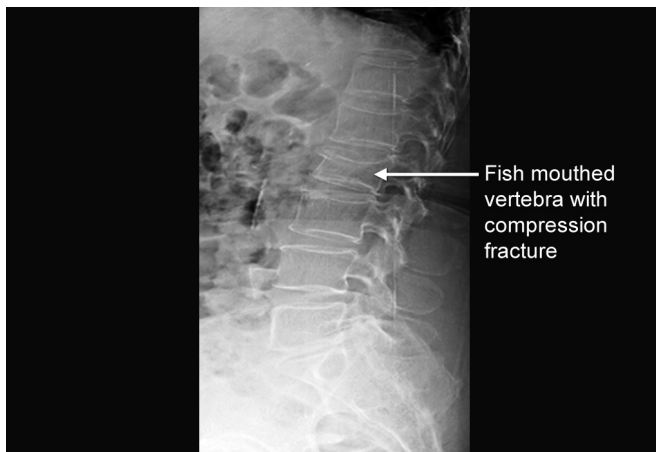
X-ray showing findings of osteoporosis.
